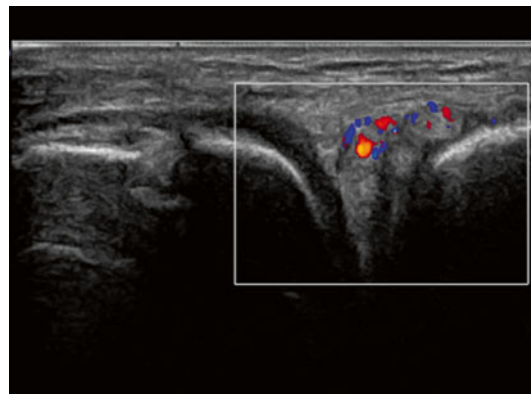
Ultrasound powerdoppler vascularisation posterior horn in healing meniscus
